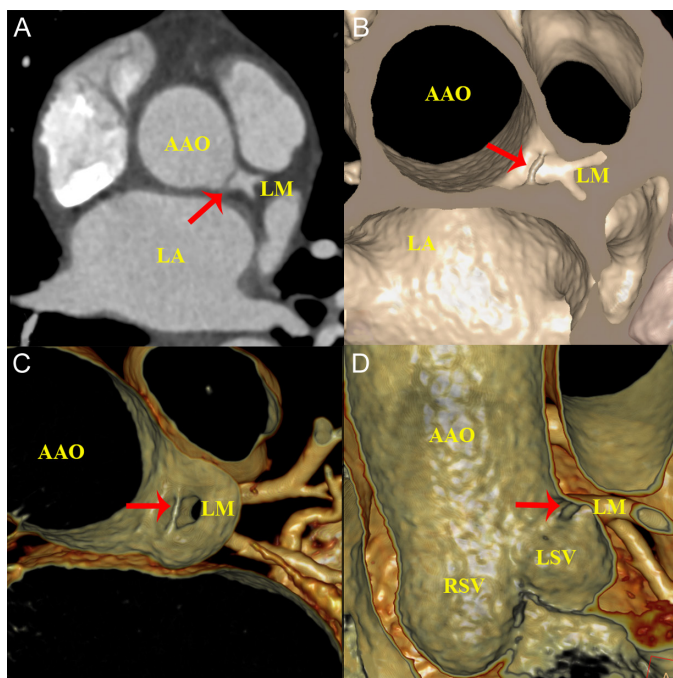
(A) Multi-planar reconstruction coronary computed tomography angiography suggested a linear, 1-2-mm thick flap crossing the main stem of the left coronary artery. (B and C) Three-dimensional endoluminal image demonstrated an intraluminal chord at an intracoronary artery lumen. (D) Three-dimensional volume rendering images with a virtual intraluminal view showed a thin linear structure crossing the main stem of the left coronary artery. LM, left main; AAO, ascending aorta; LSV, left sinus of Valsalva; RSV, right sinus of Valsalva.
